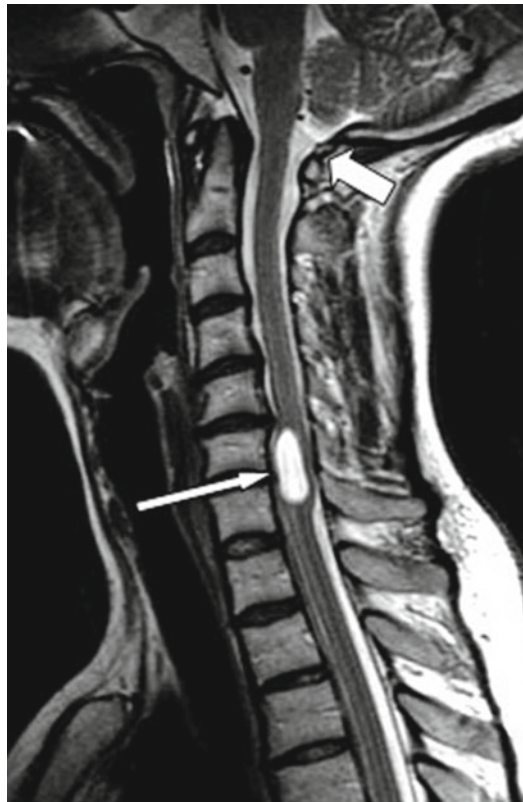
MR image of a probable gliopendymal cyst. This T2-weighted midline sagittal MRI of the cervical spine reveals a short, "plump", CSF-filled cavity within the spinal cord (*long arrow*). The craniovertebral junction is normal (*short arrow*). The disc protrusion at the upper aspect of this lesion is unlikely to be related, and this appearance most likely represents that of a gliopendymal cyst, although contrasted images are needed to exclude an underlying neoplasm
